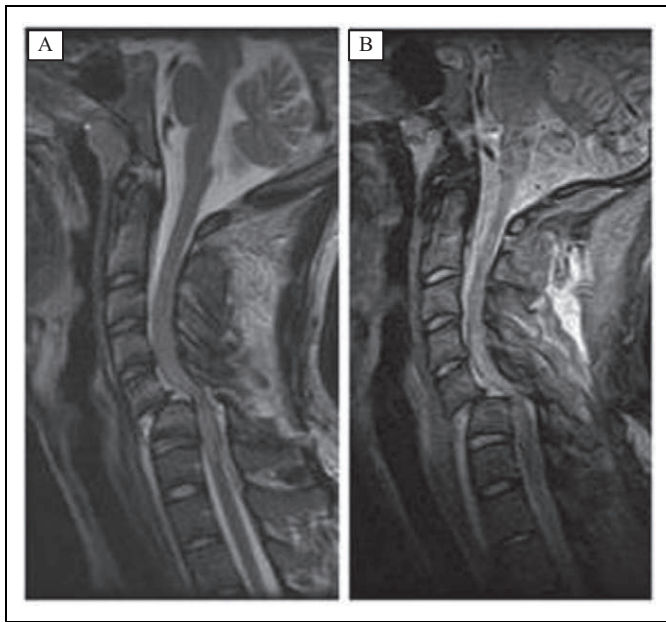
Magnetic resonance images (MRIs) of a patient with a cervical fracture subluxation as seen on a T2-weighted sagittal image (A), and STIR sagittal image (B).
